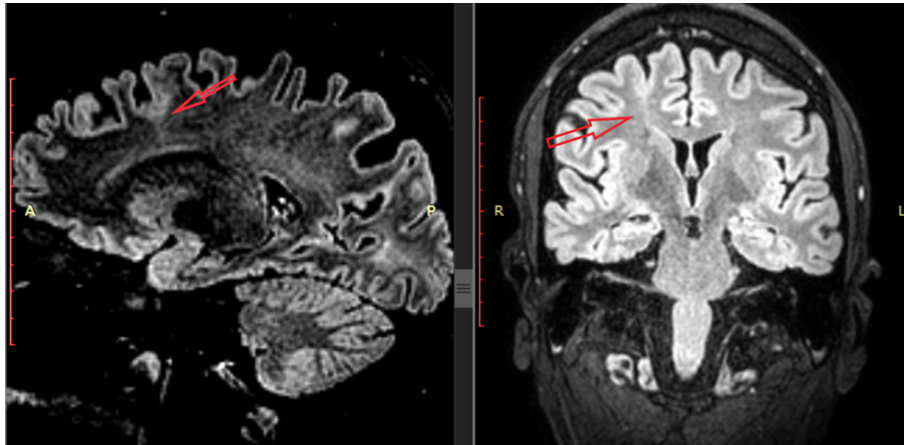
MRI (3 T) of the brain according to the protocol "epilepsy". Focal cortical dysplasia (IIB type by Blumcke classification) right frontal lobe (own observation)
